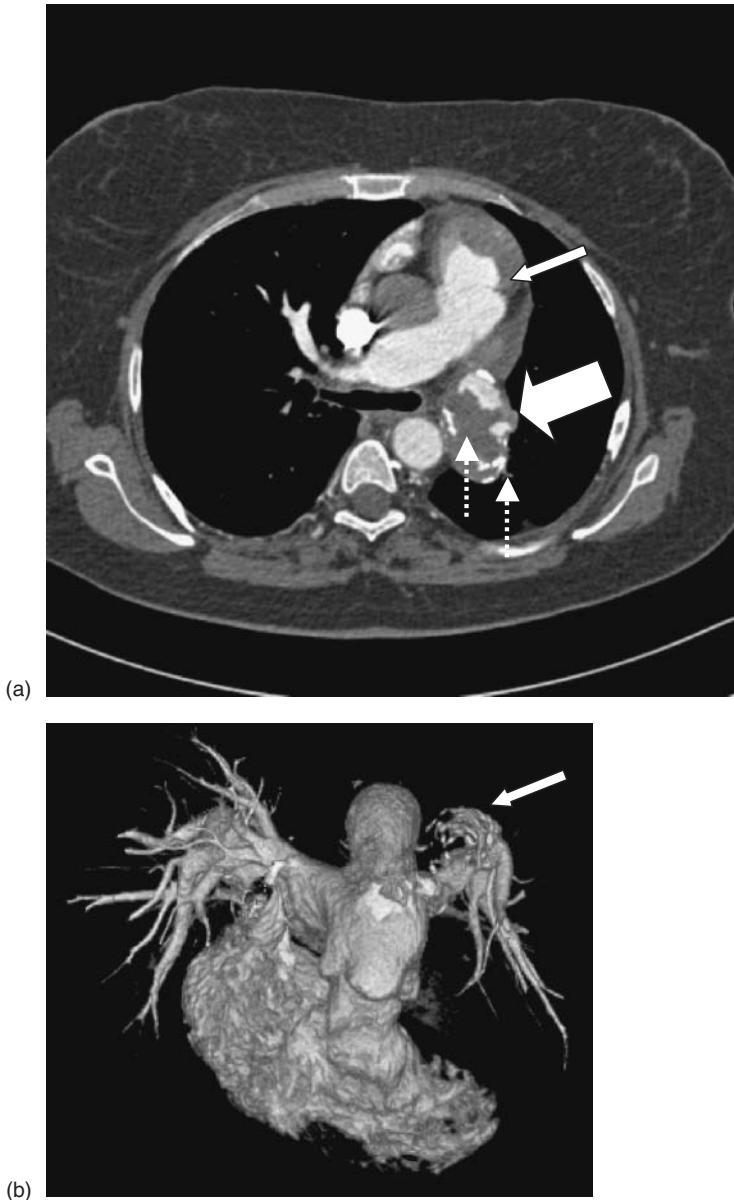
CT angiogram of patient. (a) Markedly dilated central pulmonary arteries (thin arrow); extensive in situ thrombosis in proximal left pulmonary artery (LPA) (big arrow) with calcified older thrombus (dashed arrows). (b) Three-dimensional reconstruction: filling defect in proximal LPA and occluded upper lobe branch.
